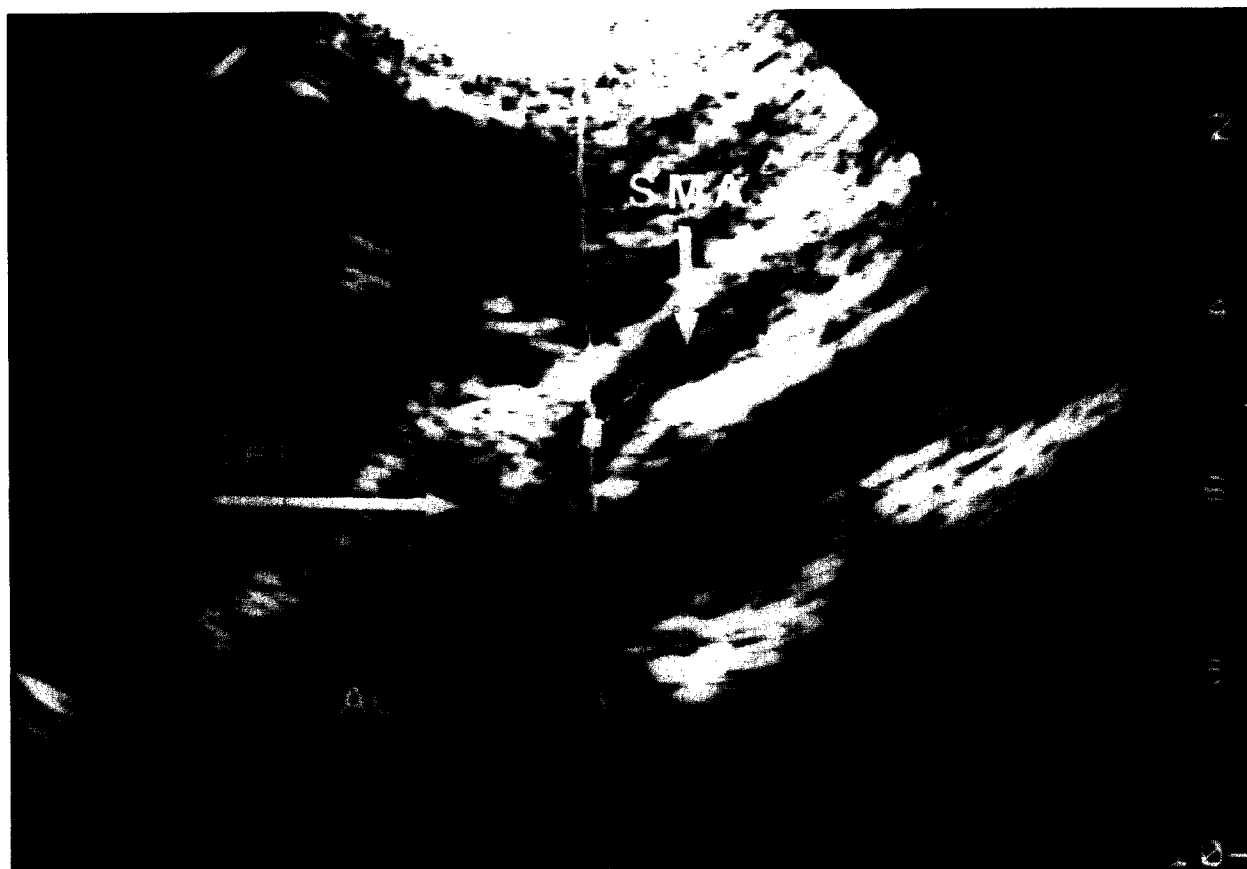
Longitudinal B-mode ultrasound view of the celiac (Cel) and superior mesenteric artery (SMA) originating from the anterior surface of the aorta (Ao). The pulsed Doppler sample volume is placed within the lumen of the SMA.
